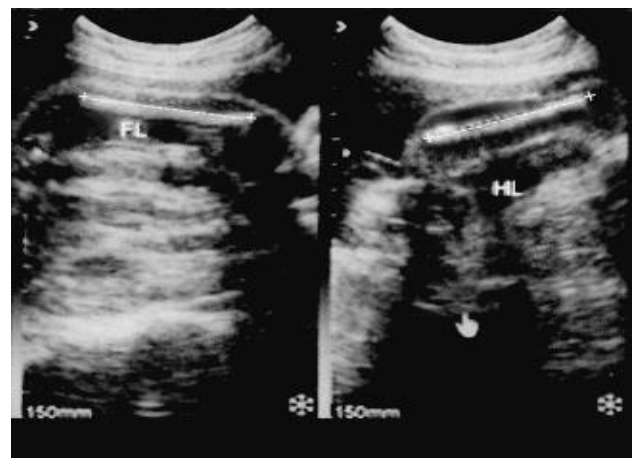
Ultrasonographic image of femur and humerus length.
